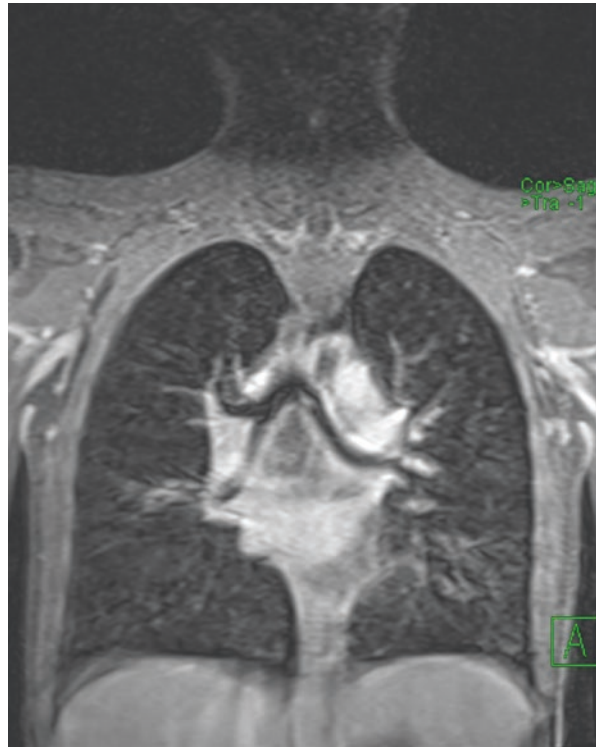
Tuberculosis reactivation after 7 months of adalimumab treatment in a 16-year-old boy with Crohn's disease. MRI shows interstitial changes, enlarged lymph nodes, infracarinal tuberculoma with colliquative necrosis
